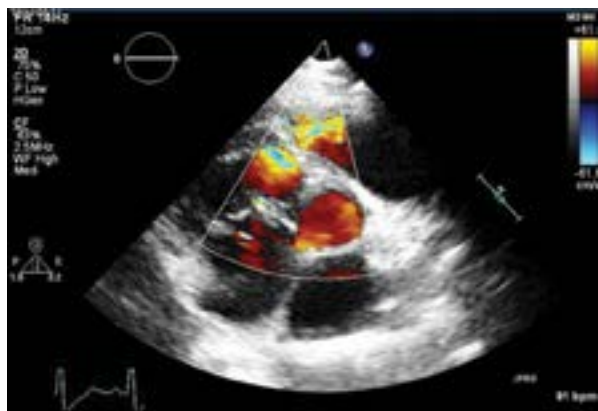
Color flow Doppler image showing the connection between two chambers of right ventricle (short axis view)
